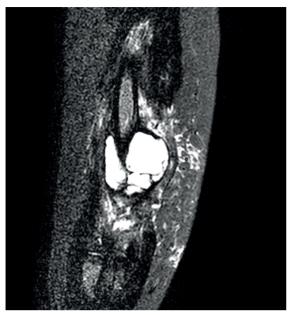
Magnetic resonance imaging of right biceps muscle showed a well defined 62x48x50-mm solid mass.
